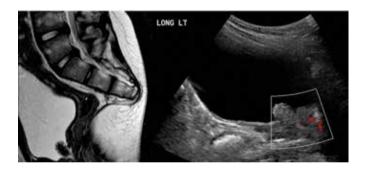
Fibroinflammatory polyp of the urinary bladder in an eightyear-old boy. The polyp was initially identified incidentally on MRI of the lumbar spine. (a) Sagittal T2-weighted MR image of the lumbar spine shows an incidentally discovered bladder lesion in the urethral orifice. (b) Sagittal color Doppler US image of the urinary bladder shows the lobulated lesion with slight internal vascularization.
